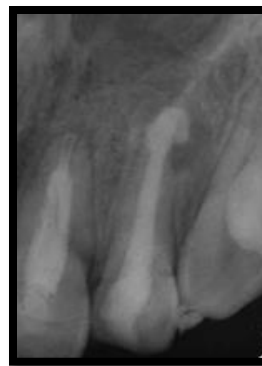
Post-operative radiograph: extruded MTA on the periapical lesion
